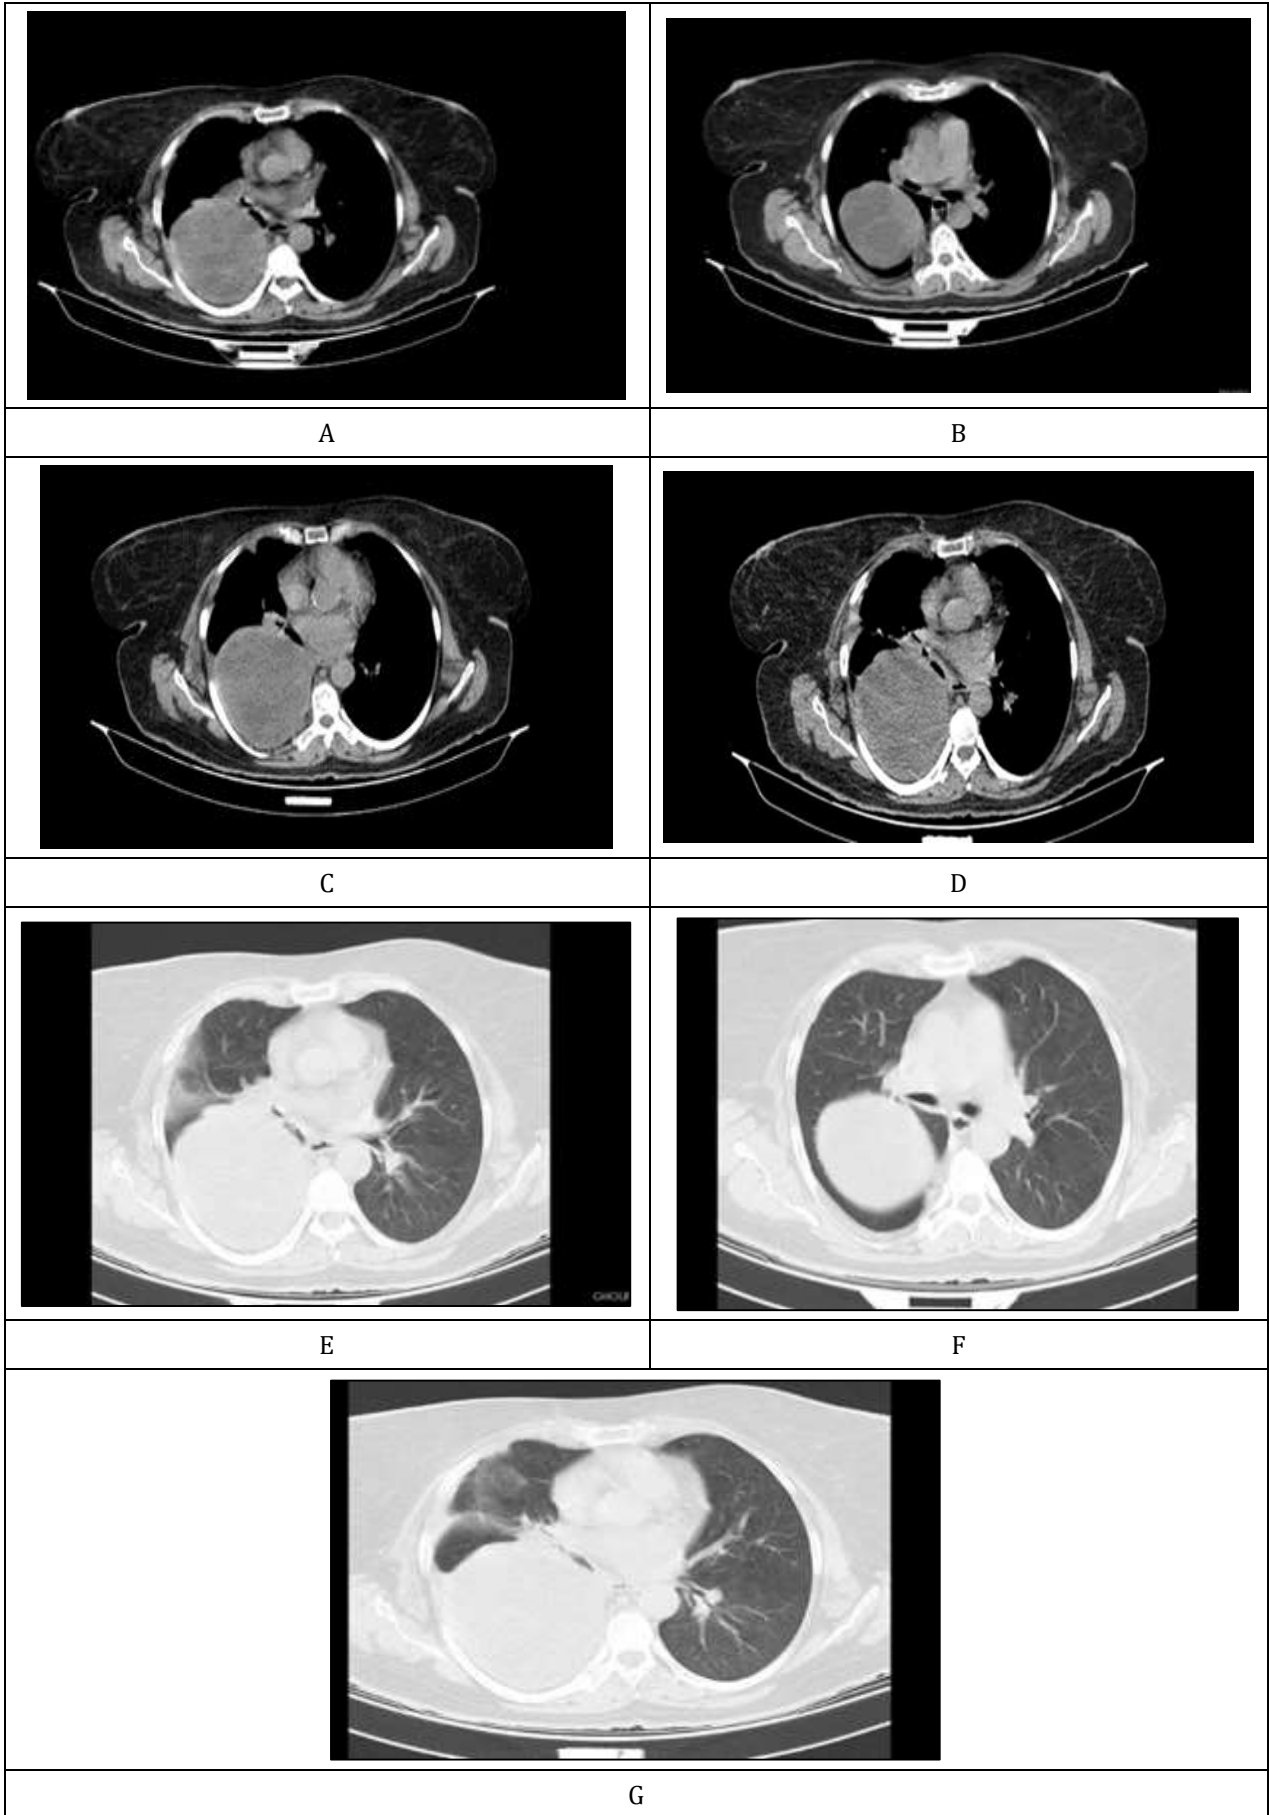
CT -scan A,B,C,D,E,F,G show solid cystic lesion
